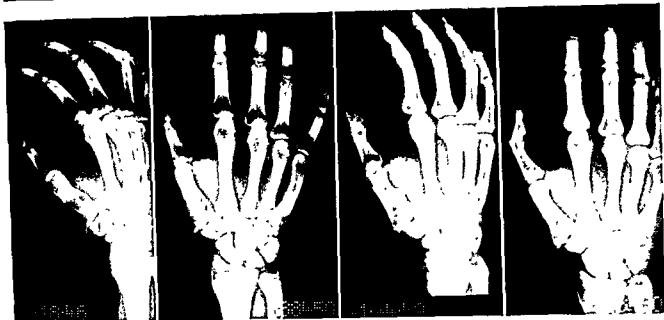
Giant-cell tumor of the metacarpal in a 31-year-old man. The lesion was treated originally by curettage, but a recurrence developed 1 year later, and in June, 1946, this was the radiographic appearance. The lesion was treated with 1,200 r (air) to 1 field. Healing progressed satisfactorily, as is shown in the films made 2½ years later. Follow-up information indicates that the patient is well 5½ years after the irradiation.
